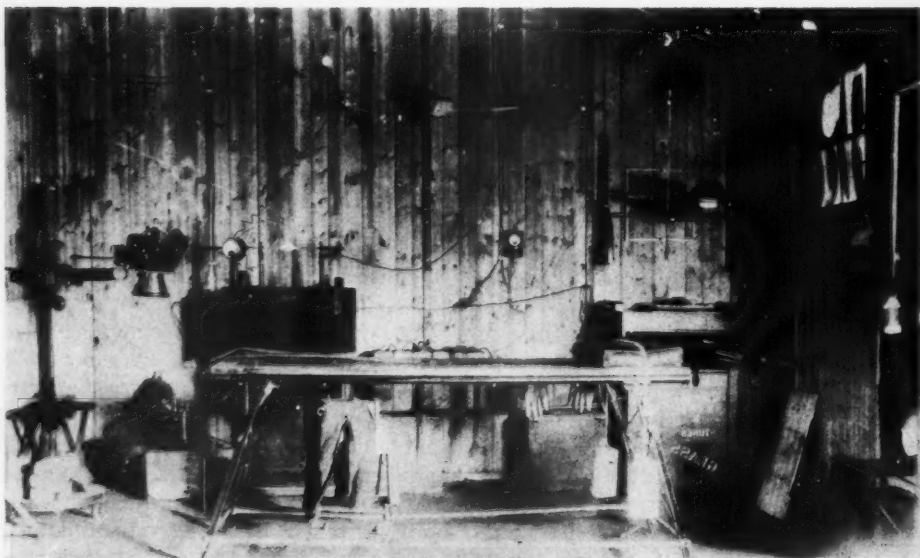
X-ray department of British General No. 12 at Rouen, France. Butts x-ray coil; spark-gap; milliamperemeter; voltmeter for testing batteries; mercury gas interrupter; gasoline engine and small dynamo for charging storage batteries; McKenzie Davidson Sweet localizer; gas x-ray tubes; wooden table and tube stand.
